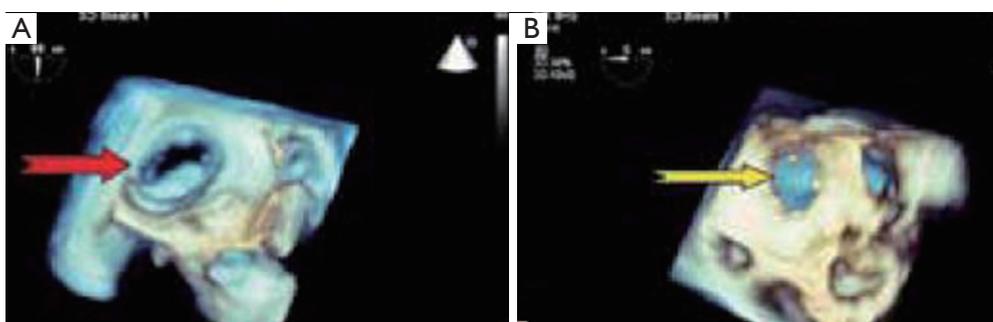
3D echocardiogram showing mitral valve and sub-valvular apparatus. Adapted with permission from Tezcan *et al.* (35). 3D, three dimension.
